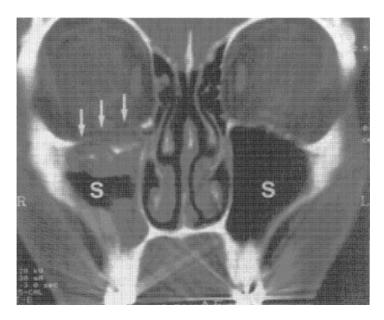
(a). Computer tomography (CT) of a 23-year old man demonstrates blow-out fracture of the right orbital floor (arrows) with herniation of orbital tissues into the maxillary sinus (S).
